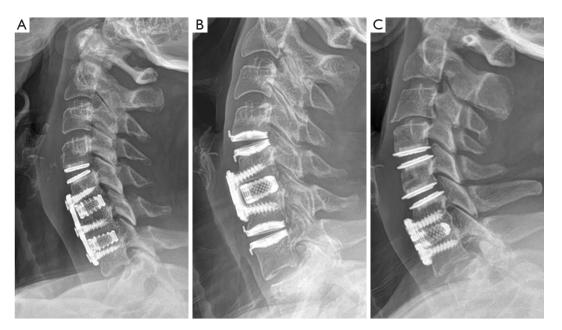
Lateral X-rays showing examples of 3-level hybrid constructs in this cohort: (A) arthroplasty/fusion/fusion, (B) arthroplasty/fusion/ arthroplasty, and (C) arthroplasty/arthroplasty/fusion.
